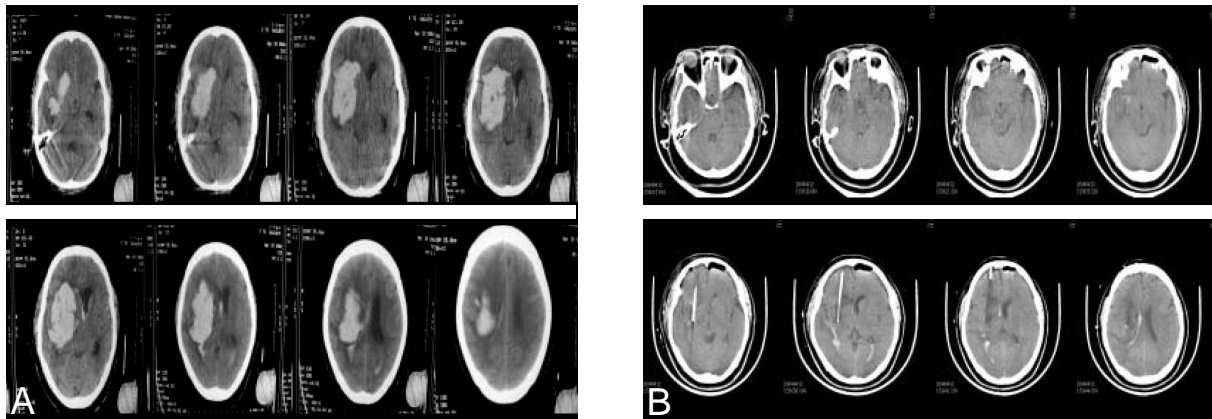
Patient 8: a 65-year-old woman presented with sudden disturbance of consciousness. A: CT scans at admission show right putaminal hemorrhage; the volume was 100 mL. B: Postoperative CT scans show only 3 mL hematoma remaining. (frontal approach)
